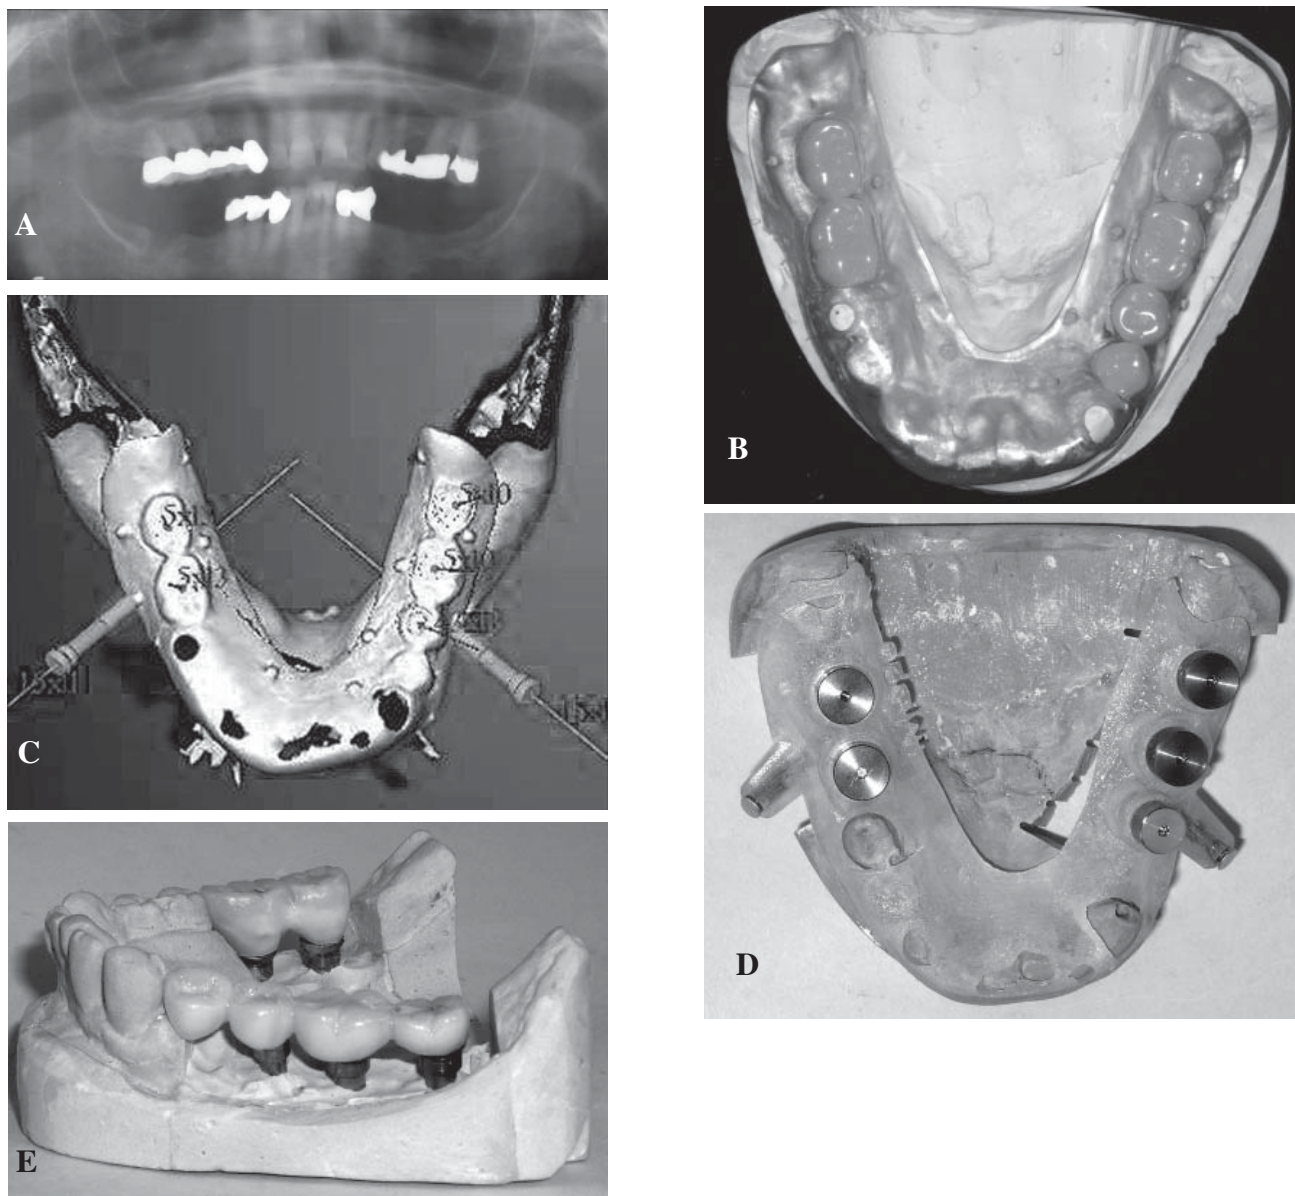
Treatment planning for a 65-year-old female with a bilateral partially edentulous mandible. A. Pre-operative panoramic radiograph, B. Mandibular scan prosthesis, C. Occlusal view of the virtual treatment plan, NobelGuide™, D. Model cut out posteriorly to show the implant analogs secured bilaterally in the NobelGuide™, E. Provisional restoration with an internal titanium framework, fabricated prior to implant placement surgery.
